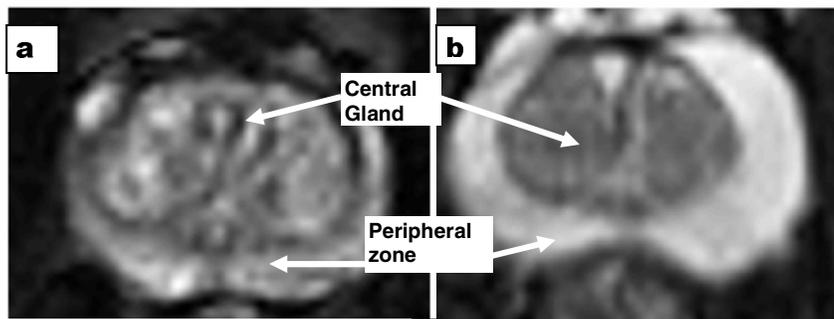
Central slices through T2 fat-suppressed MR images of the prostate showing: (a) the granular, inhomogeneous appearance of the central gland and compressed peripheral zone in glandular (non-stromal) BPH; (b) the more homogeneous appearance of the central gland and larger peripheral zone in stromal BPH
